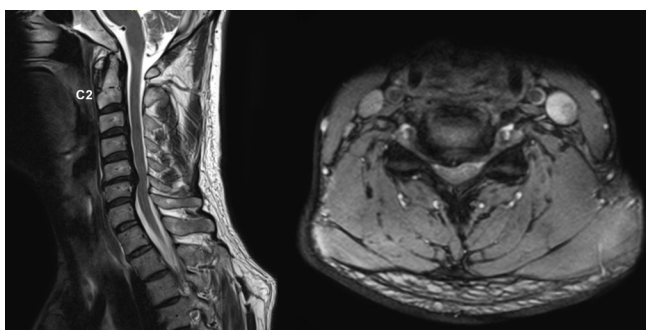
Sagittal and axial MRI images show a large central-right paracentral protrusion resulting in narrowing the spinal channel at the level of C5-C6 with posterior longitudinal ligament thickening and spinal cord compression. Bilateral foraminal stenosis at this level is present.
